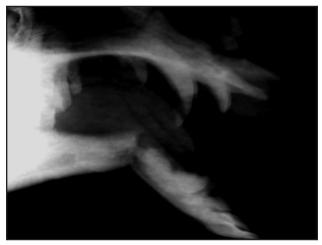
A latero-medial radiograph of camel as shown in Fig showing a transverse mandible fracture at the alveoli of tushes. Note the abnormal angulation cranial to the fracture site.
